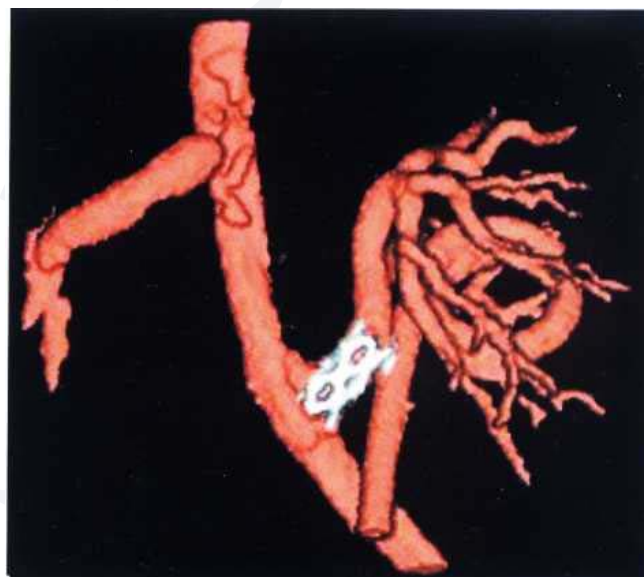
3D segmented CT angiogram image of renal transplant artery with arterial stent.
